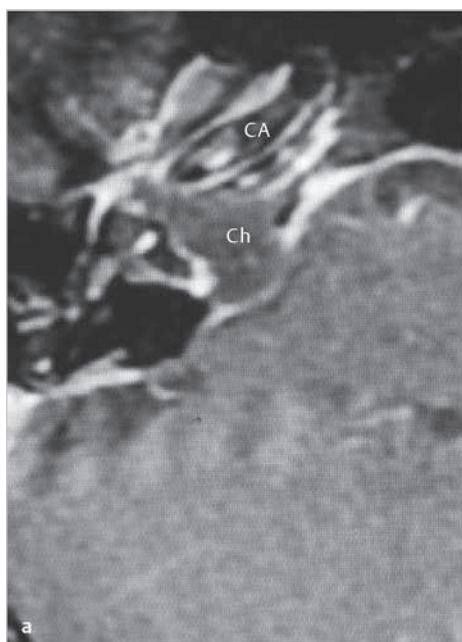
The MRI shows a mass of moderate signal intensity in T1 with no enhancement with gadolinium, and mosaic of high and moderate signal intensity in T2. The internal auditory canal (*yellow arrow*) is infiltrated by the cholesteatoma. Signal intensity of the cochlea in T2 is decreased suggesting either fibrosis or ossification. CA, carotid artery; Ch, cholesteatoma.
